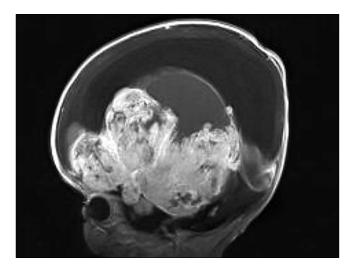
MRI axial post-contrast T1WI shows a large heterogeneous lesion with irregular enhancement. The lesion causes obstructive hydrocephalus involving the lateral ventricles.
